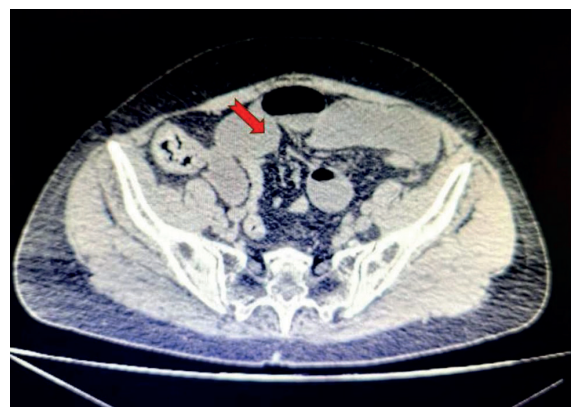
Abdominal CT scan showing dilated small intestine loops in the pelvic region and a transition zone indicating luminal narrowing in the ileal loops
